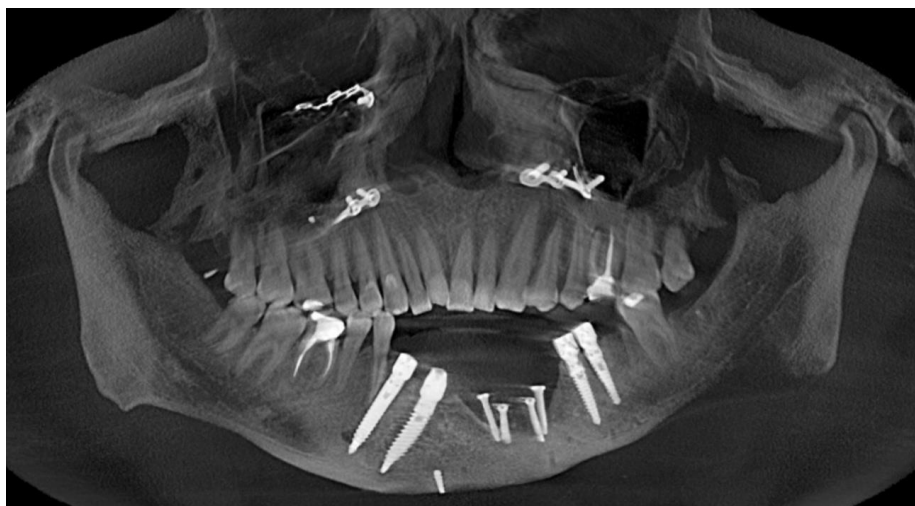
Control CT-scan after surgery, implants and expander have been placed.
